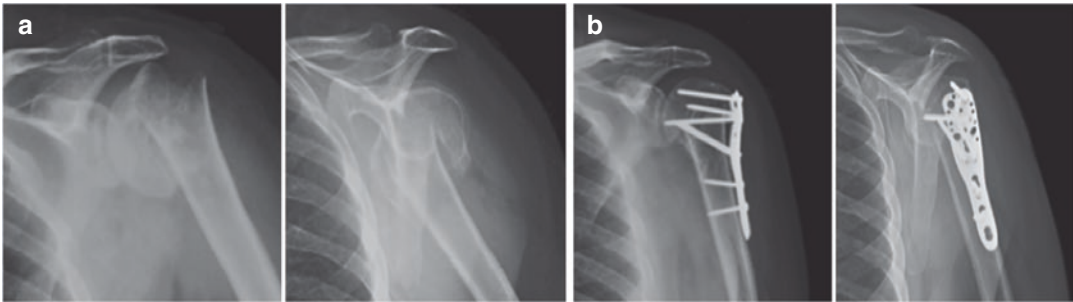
(a) Displaced proximal humeral fracture in a 73-year-old female. (b) Radiographical outcome after treatment with open reduction and internal fixation with locking plate
